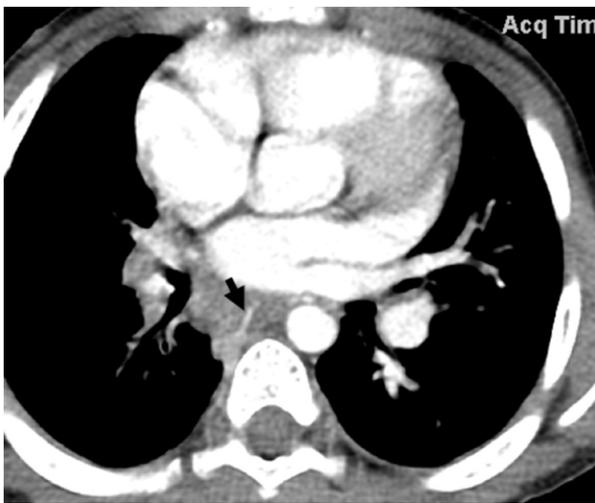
Axial contrast enhanced CT image of the chest at age 6 years. The soft tissue process in the posterior mediastinum and involving the right hilum is stable. A prominent vessel (arrow) is again seen coursing through the posterior mediastinal soft tissue process. While the left pulmonary veins are present, the right pulmonary veins are absent.
